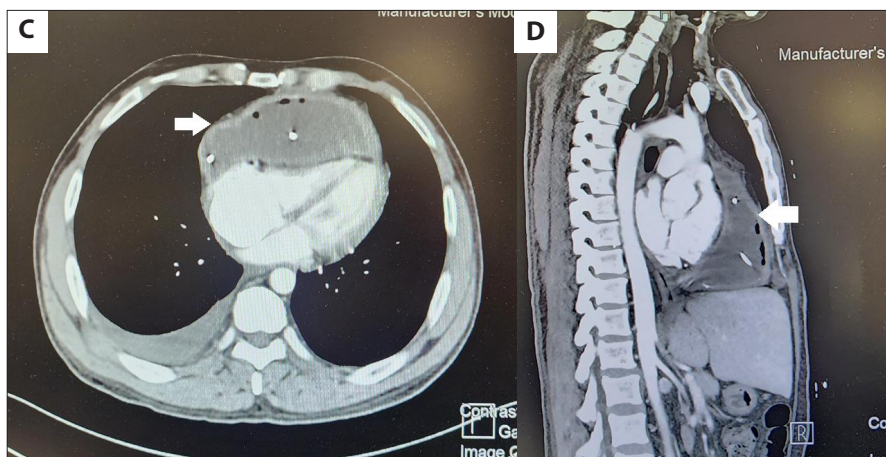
Axial (C) and sagittal (D) computed tomography scans of the chest and upper abdomen preoperatively. White arrows indicate the pericardial cyst and associated mass effect.
